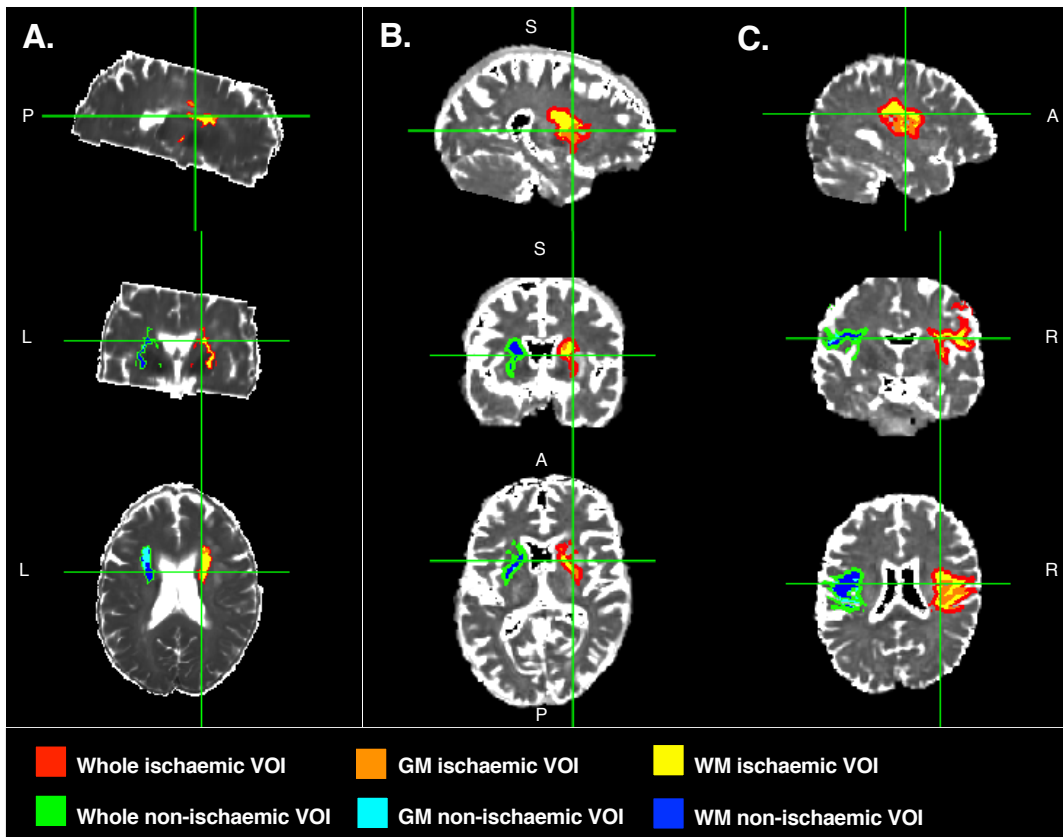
Examples of contiguous VOIs containing the whole ischaemic region, only GM and only WM, from three patients with different onset times. VOIs are overlaid on the T₂ relaxation time maps. A. 69-year-old female patient with right total anterior circulation stroke (TACS), thrombolysed, NIHSS on admission = 21, time from symptom onset to MRI = 184 minutes, scanned at the Bristol site. B. 71-year-old male patient with right partial anterior circulation stroke (PACS), thrombolysed, NIHSS on admission = 7, time from symptom onset to MRI = 334 minutes, scanned at the Glasgow site. C. 64-year-old male patient with right TACS, thrombolysed, NIHSS on admission = 9, time from symptom onset to MRI = 452 minutes, scanned at the Glasgow site.
